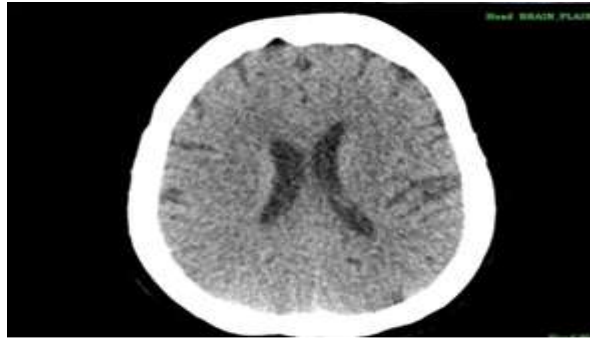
Plain CT of the brain showing a hypodense area in the left temporal region, consistent with an acute infarct.
